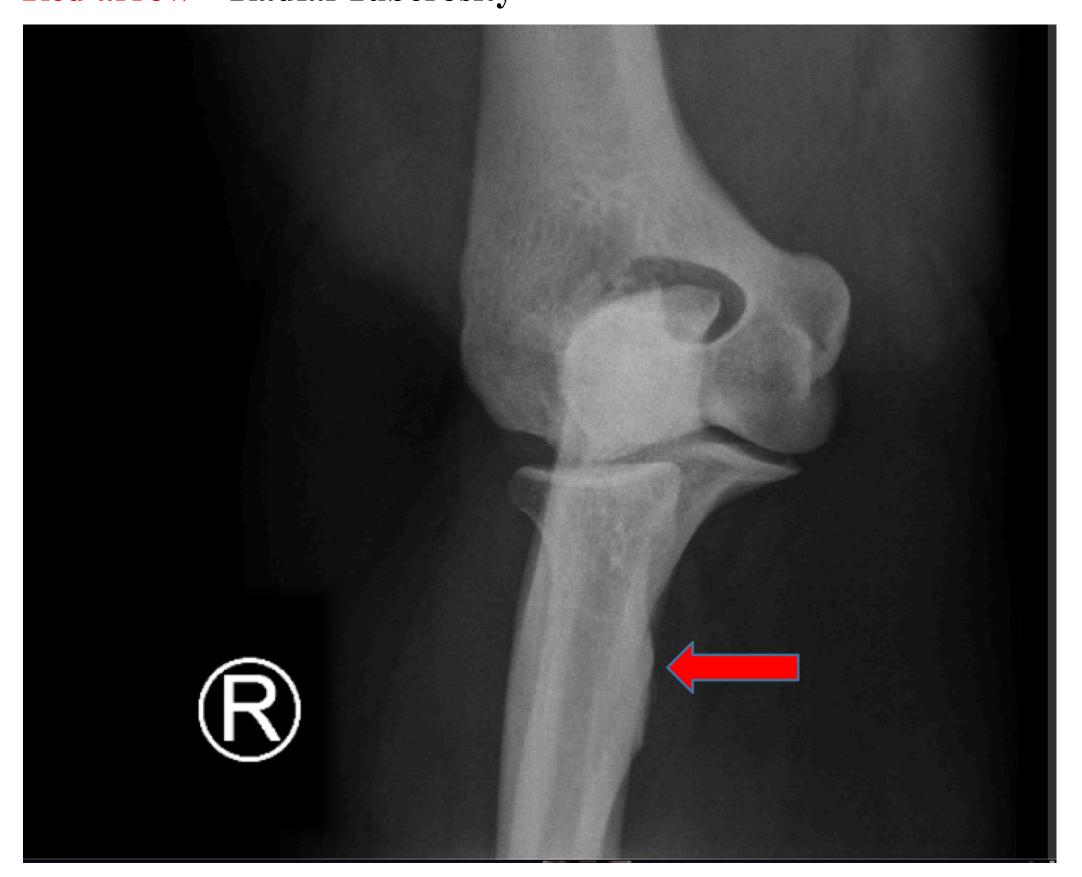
X-ray of Right Elbow, Lateral Oblique view Red arrow – Radial Tuberosity
